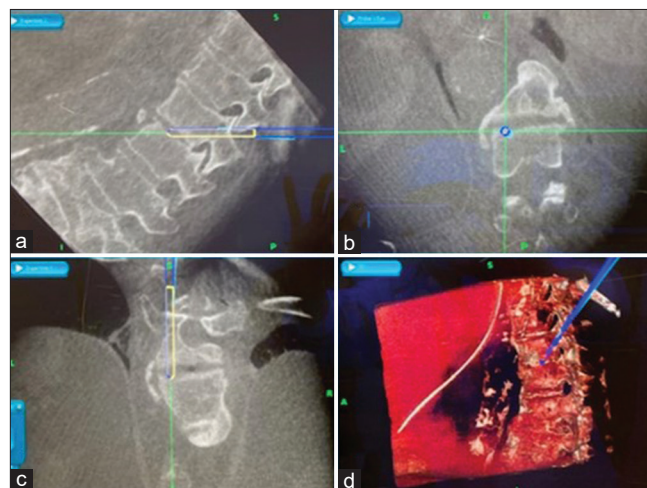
Screenshot from the O-arm image guidance system showing the intraoperative planned trajectory. (a) Sagittal view, (b) coronal view, white line; screw, green line; direction of insertion, blue line and circle; screwdriver. (c) axial view, and (d) 3D reconstructed cone-beam CT imaging.
